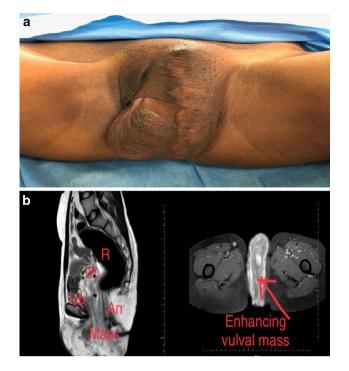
a Preoperative image of a huge left vulval mass. b (i) Sagittal T2 MRI image showing mass, Ub—urinary bladder, Ut—uterus, R—rectum, An—anal canal. (ii) Coronal T1 MRI image showing contrast enhancing vulval mass
